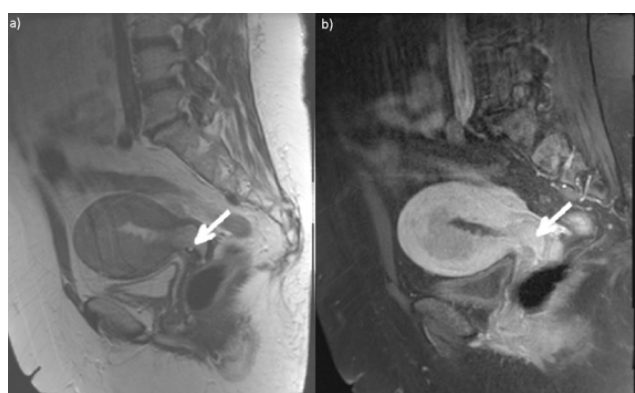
Pelvic MRI: a) T2W and b) T1W C+ images show a tumor protruding into the cervical canal with the affected epithelium of the cervical glands and intact stroma (arrows) (stage I).
